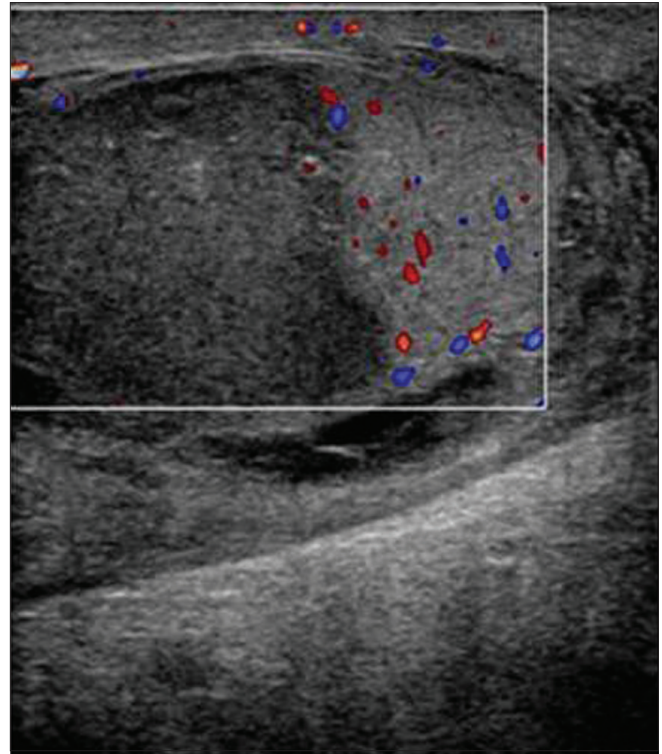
Absence of vascularity on Doppler sonography
